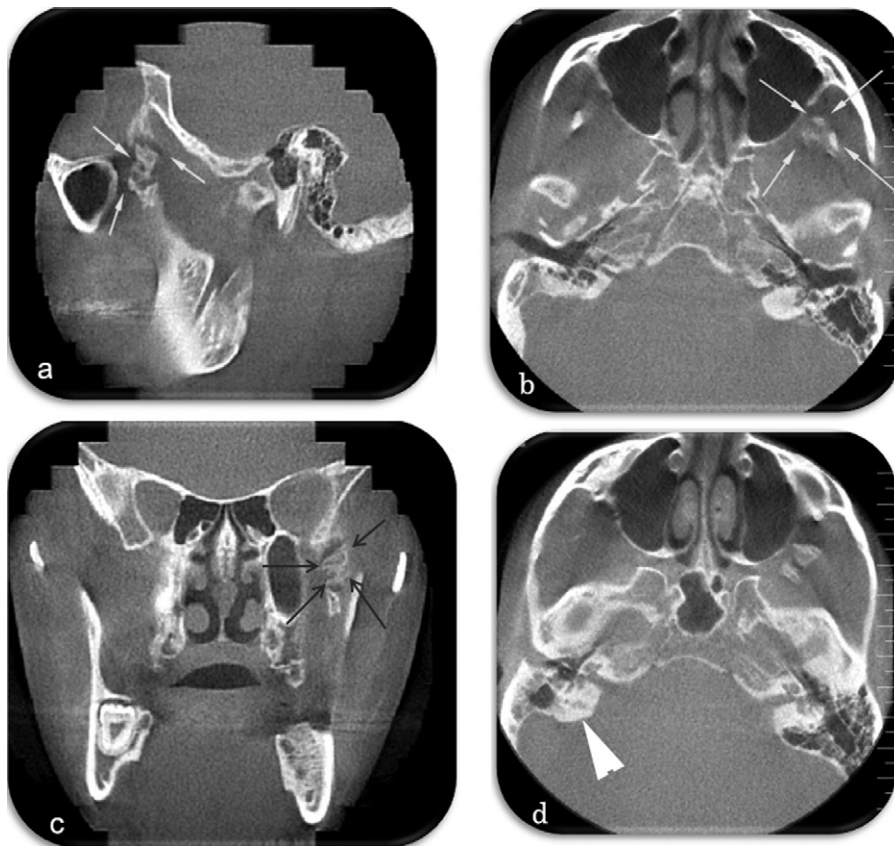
a–c, Sagittal, axial, and coronal CBCT images show a radiopaque ossification under the left zygomatic arch through the skull base (*arrows*). The relationship between the surrounding muscles cannot be visualized on CBCT images. d, The axial image also shows marked opacification in the right mastoid region (*arrowhead*).
